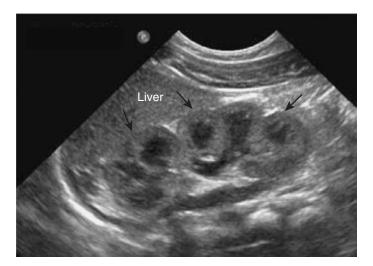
Renal ultrasound in a normal term infant. Fetal lobulations (arrows) are seen on the surface of the kidney. The renal cortex is more echogenic than the liver and the prominent renal pyramids are hypoechoic.
